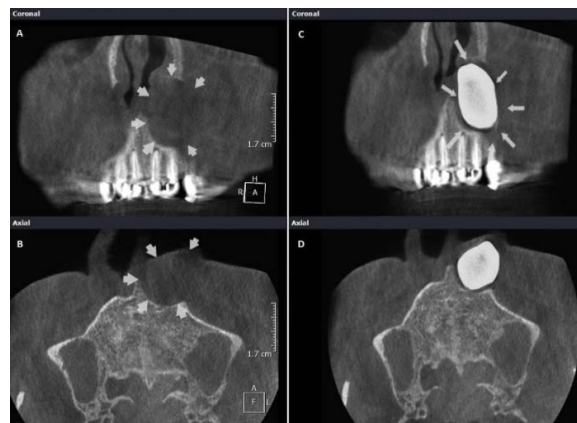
Cone Beam Computed Tomography images before and after injection of contrast media. (A) Coronal and (B) Axial pre-injection CBCT images. Erosion of anterior maxilla and displacement of anterior nasal floor can be detected. Arrows indicate detectable margins of the lesion. (C) Coronal and (D) Axial images showing high attenuation within the cyst located in the left nasolabial fold following injection with contrast media. The lining of the cyst is visualized between cystic contents and supporting bones
